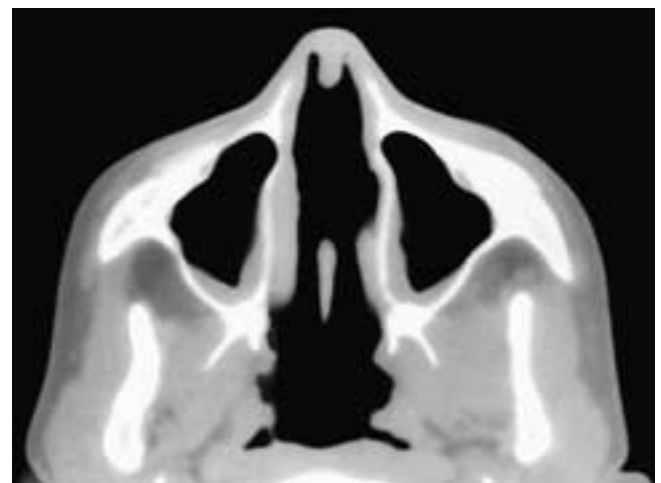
Axial CT scan shows a large erosion of the nasal septum and minimal mucosal thickening in the maxillary sinuses. This appearance suggests a granulomatous process. This patient was a chronic cocaine abuser.
